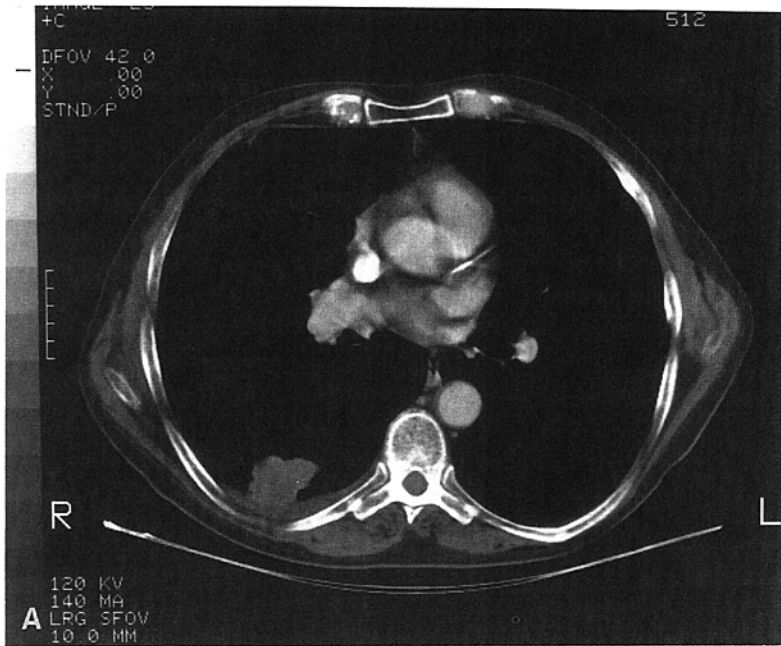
Metastatic squamous cell carcinoma producing a pleural-based mass. (A) CT of the lower thorax demonstrates a pleural-based mass with adjacent pleural thickening. The mass is inhomogeneous, suggesting necrosis. (B) High-resolution sonogram of the right posterior chest demonstrates the pleural thickening (arrow). A small pleural effusion (asterisk) and a solid tumor mass with central necrosis (open arrows) produces a low echogenic focus. Biopsy used ultrasound guidance.
